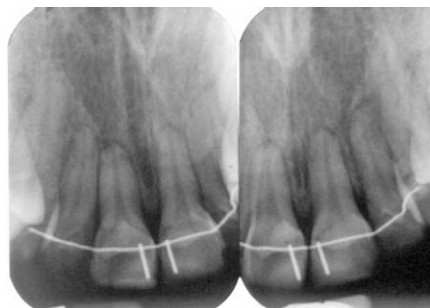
Final periapical radiograph.
